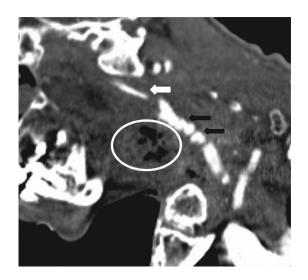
CT image of vessel wall irregularities (black arrows) in CCA, luminal narrowing (white arrow) in ICA and air bubbles (white round) which indicating skin fistula development.
